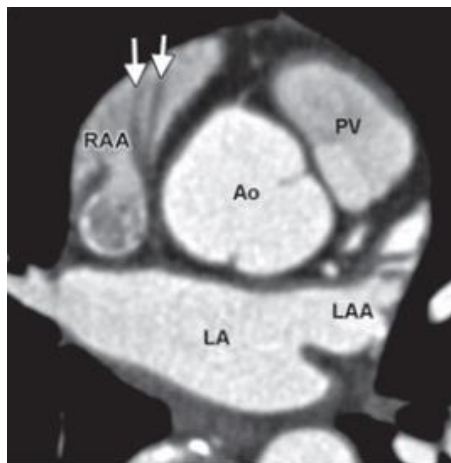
CT axial view showing the right atrial appendage (RAA) has broader opening and prominent pectinate muscle (arrows) while the left one has a finger like shape (*Leschka et al., 2007*).
